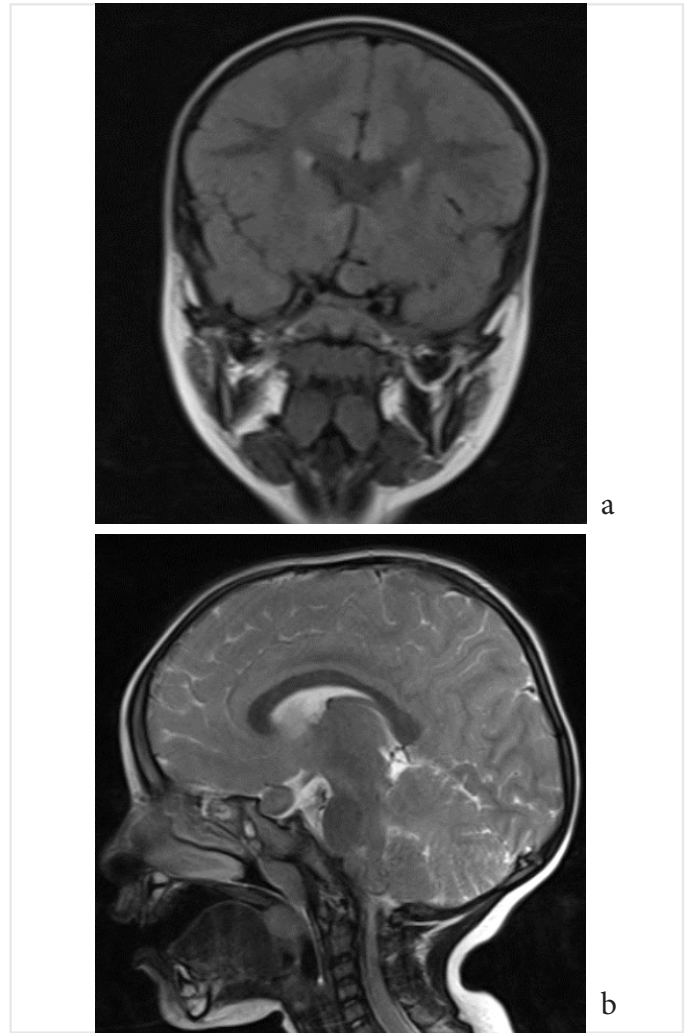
A seven-year-old patient with NF1 with optic glioma. Optic glioma is observed on the left side of the optic chiasm in coronal FLAIR (a) and sagittal T2 (b) images
